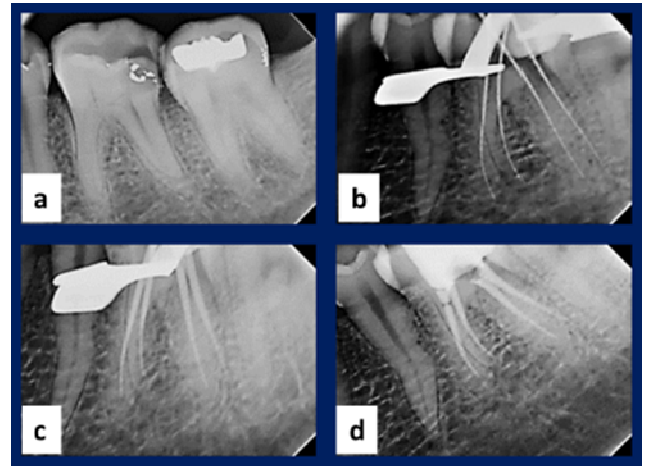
Pre op radiograph. b) Working length determination radiograph c) Master cone selection radiograph. d) Post obturation radiograph
